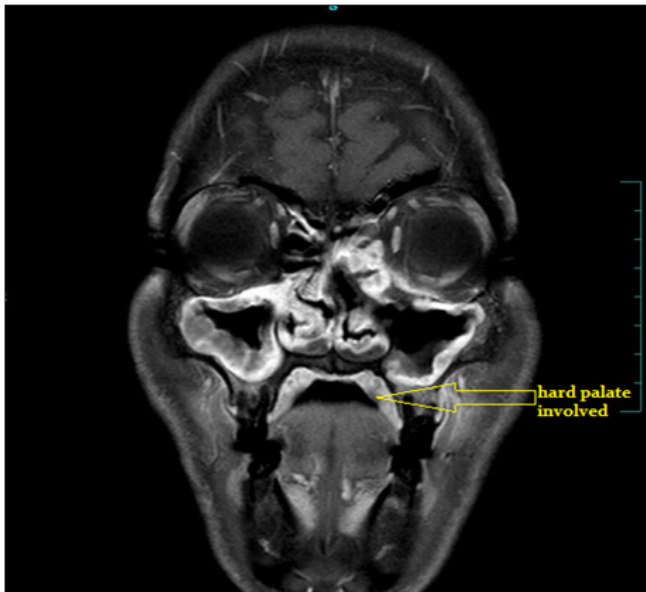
A T2 Weighted Contrast Enhanced MRI of the Same Patient Showing Hyperintense Signals in the Entire Hard Palate, Mucosal Lining of all the Paranasal Sinuses and Left Intraorbital area Suggesting Involvement and Disease Progression in all these Structures
